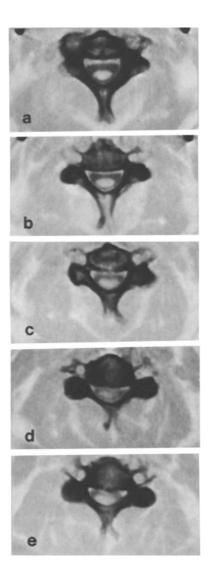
a-e. Congenitally narrow cervical spinal canal (metrizamideenhancement / CT-myelogram). <u>a-c</u> Scans at level of C 2, C 2/3 and C 3 showing relatively wide subarachnoid space and thin cord. <u>d</u> Scan at level of C 4/5 interspace showing extreme anterior-posterior flattening of spinal cord and very narrow subarachnoid space secondary to constitutional narrowness of spinal canal plus posterior spondylosis. <u>e</u> Scan at level of C 5
